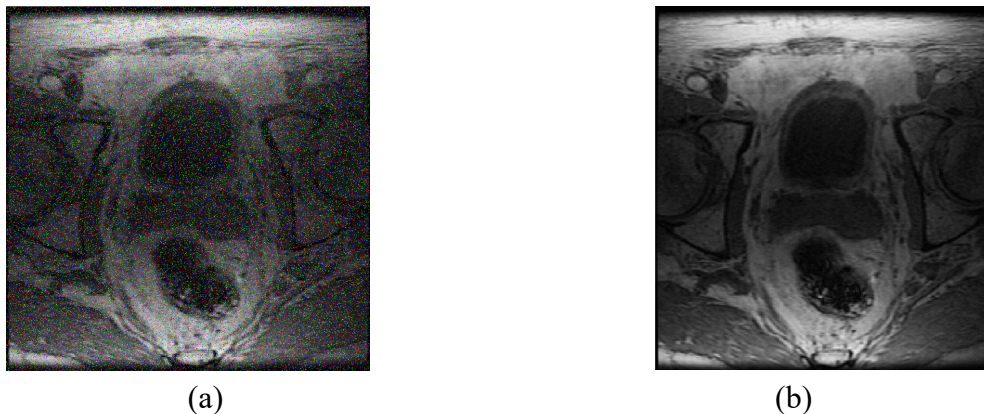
Comparison of prostate MRI images before and after denoising: (a) original image, (b) denoised image.
